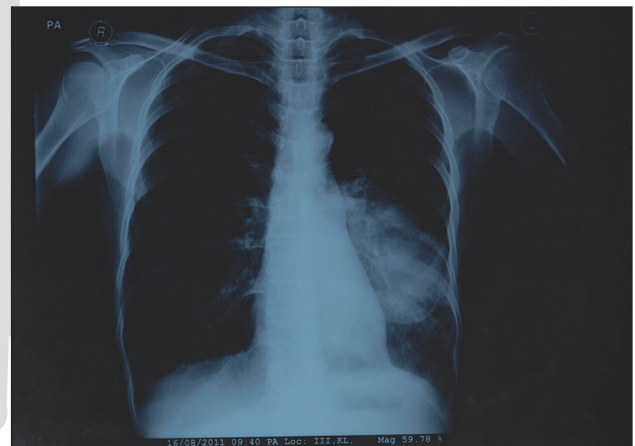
PA chest radiograph revealed tumor mass in left lung
